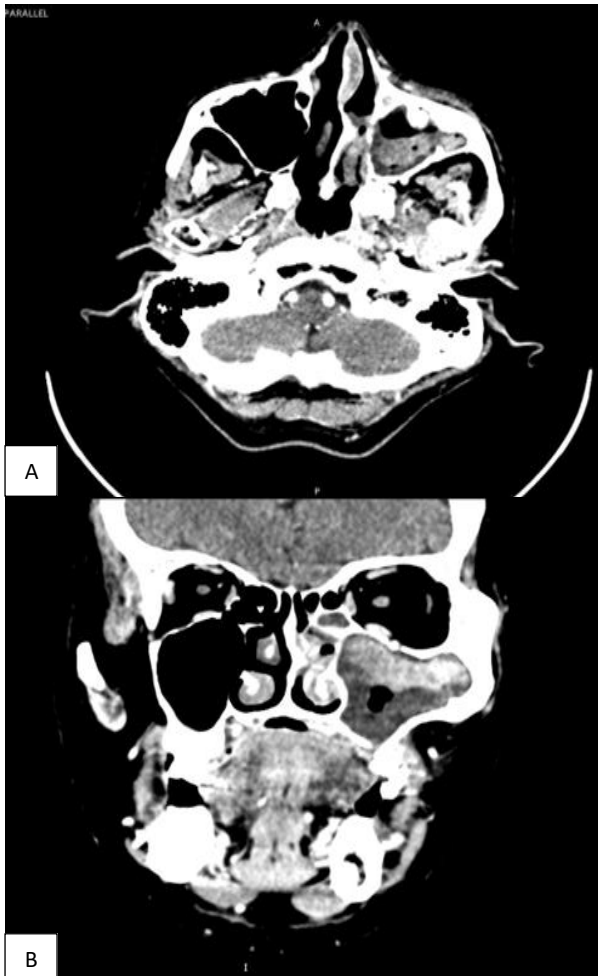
(A and B): Simple and contrast-enhanced CT of the skull, coronal and sagittal sections, demonstrating a lesion consistent with soft tissue of heterogeneous density, showing changes compatible with necrosis vs. hemorrhage, occupying the entire left maxillary sinus with bony extension into the nasal cavity, ethmoid sinuses, and floor of the orbit.
